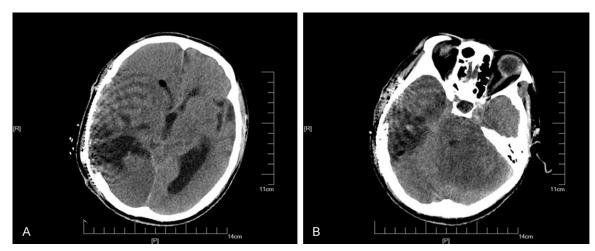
Six hours later, postoperative immediate CT scan shown hypo-dense lesions in the right cerebral (A) and the left cerebellar lobes (B).
